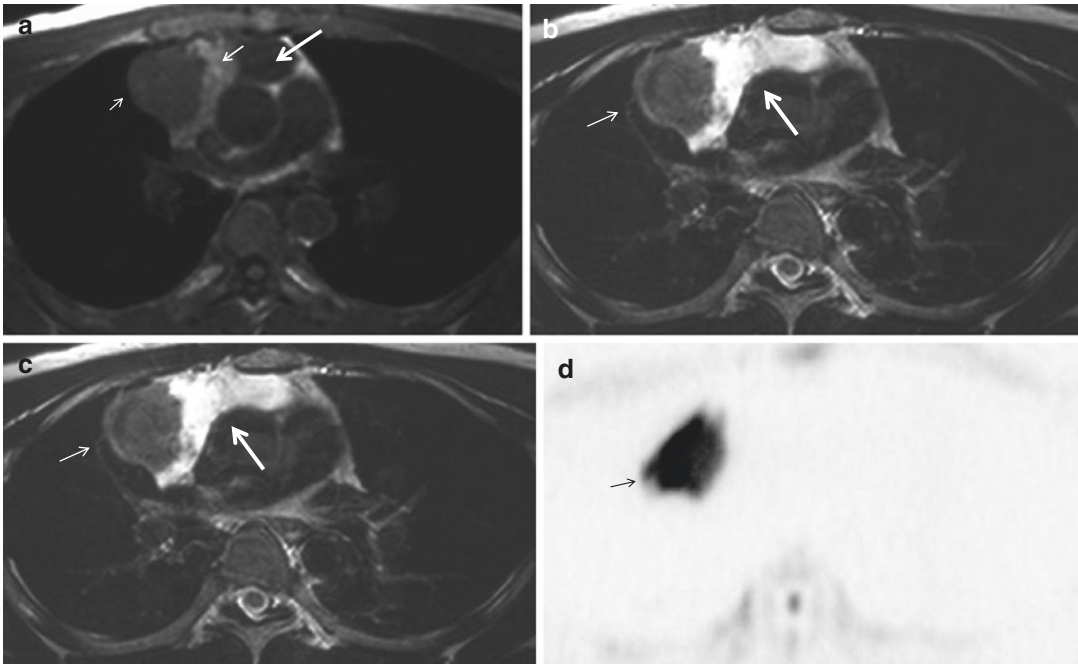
Hodgkin’s lymphoma associated with a thymic cyst. On T1-weighted image (a), the lymphoma (small arrow) shows intermediate signal similar to muscle, and the thymic cyst consists of high (medium arrow) and low signal (large arrow). On T2-weighted image (b), the lymphoma shows intermediate signal (small arrow), whereas
